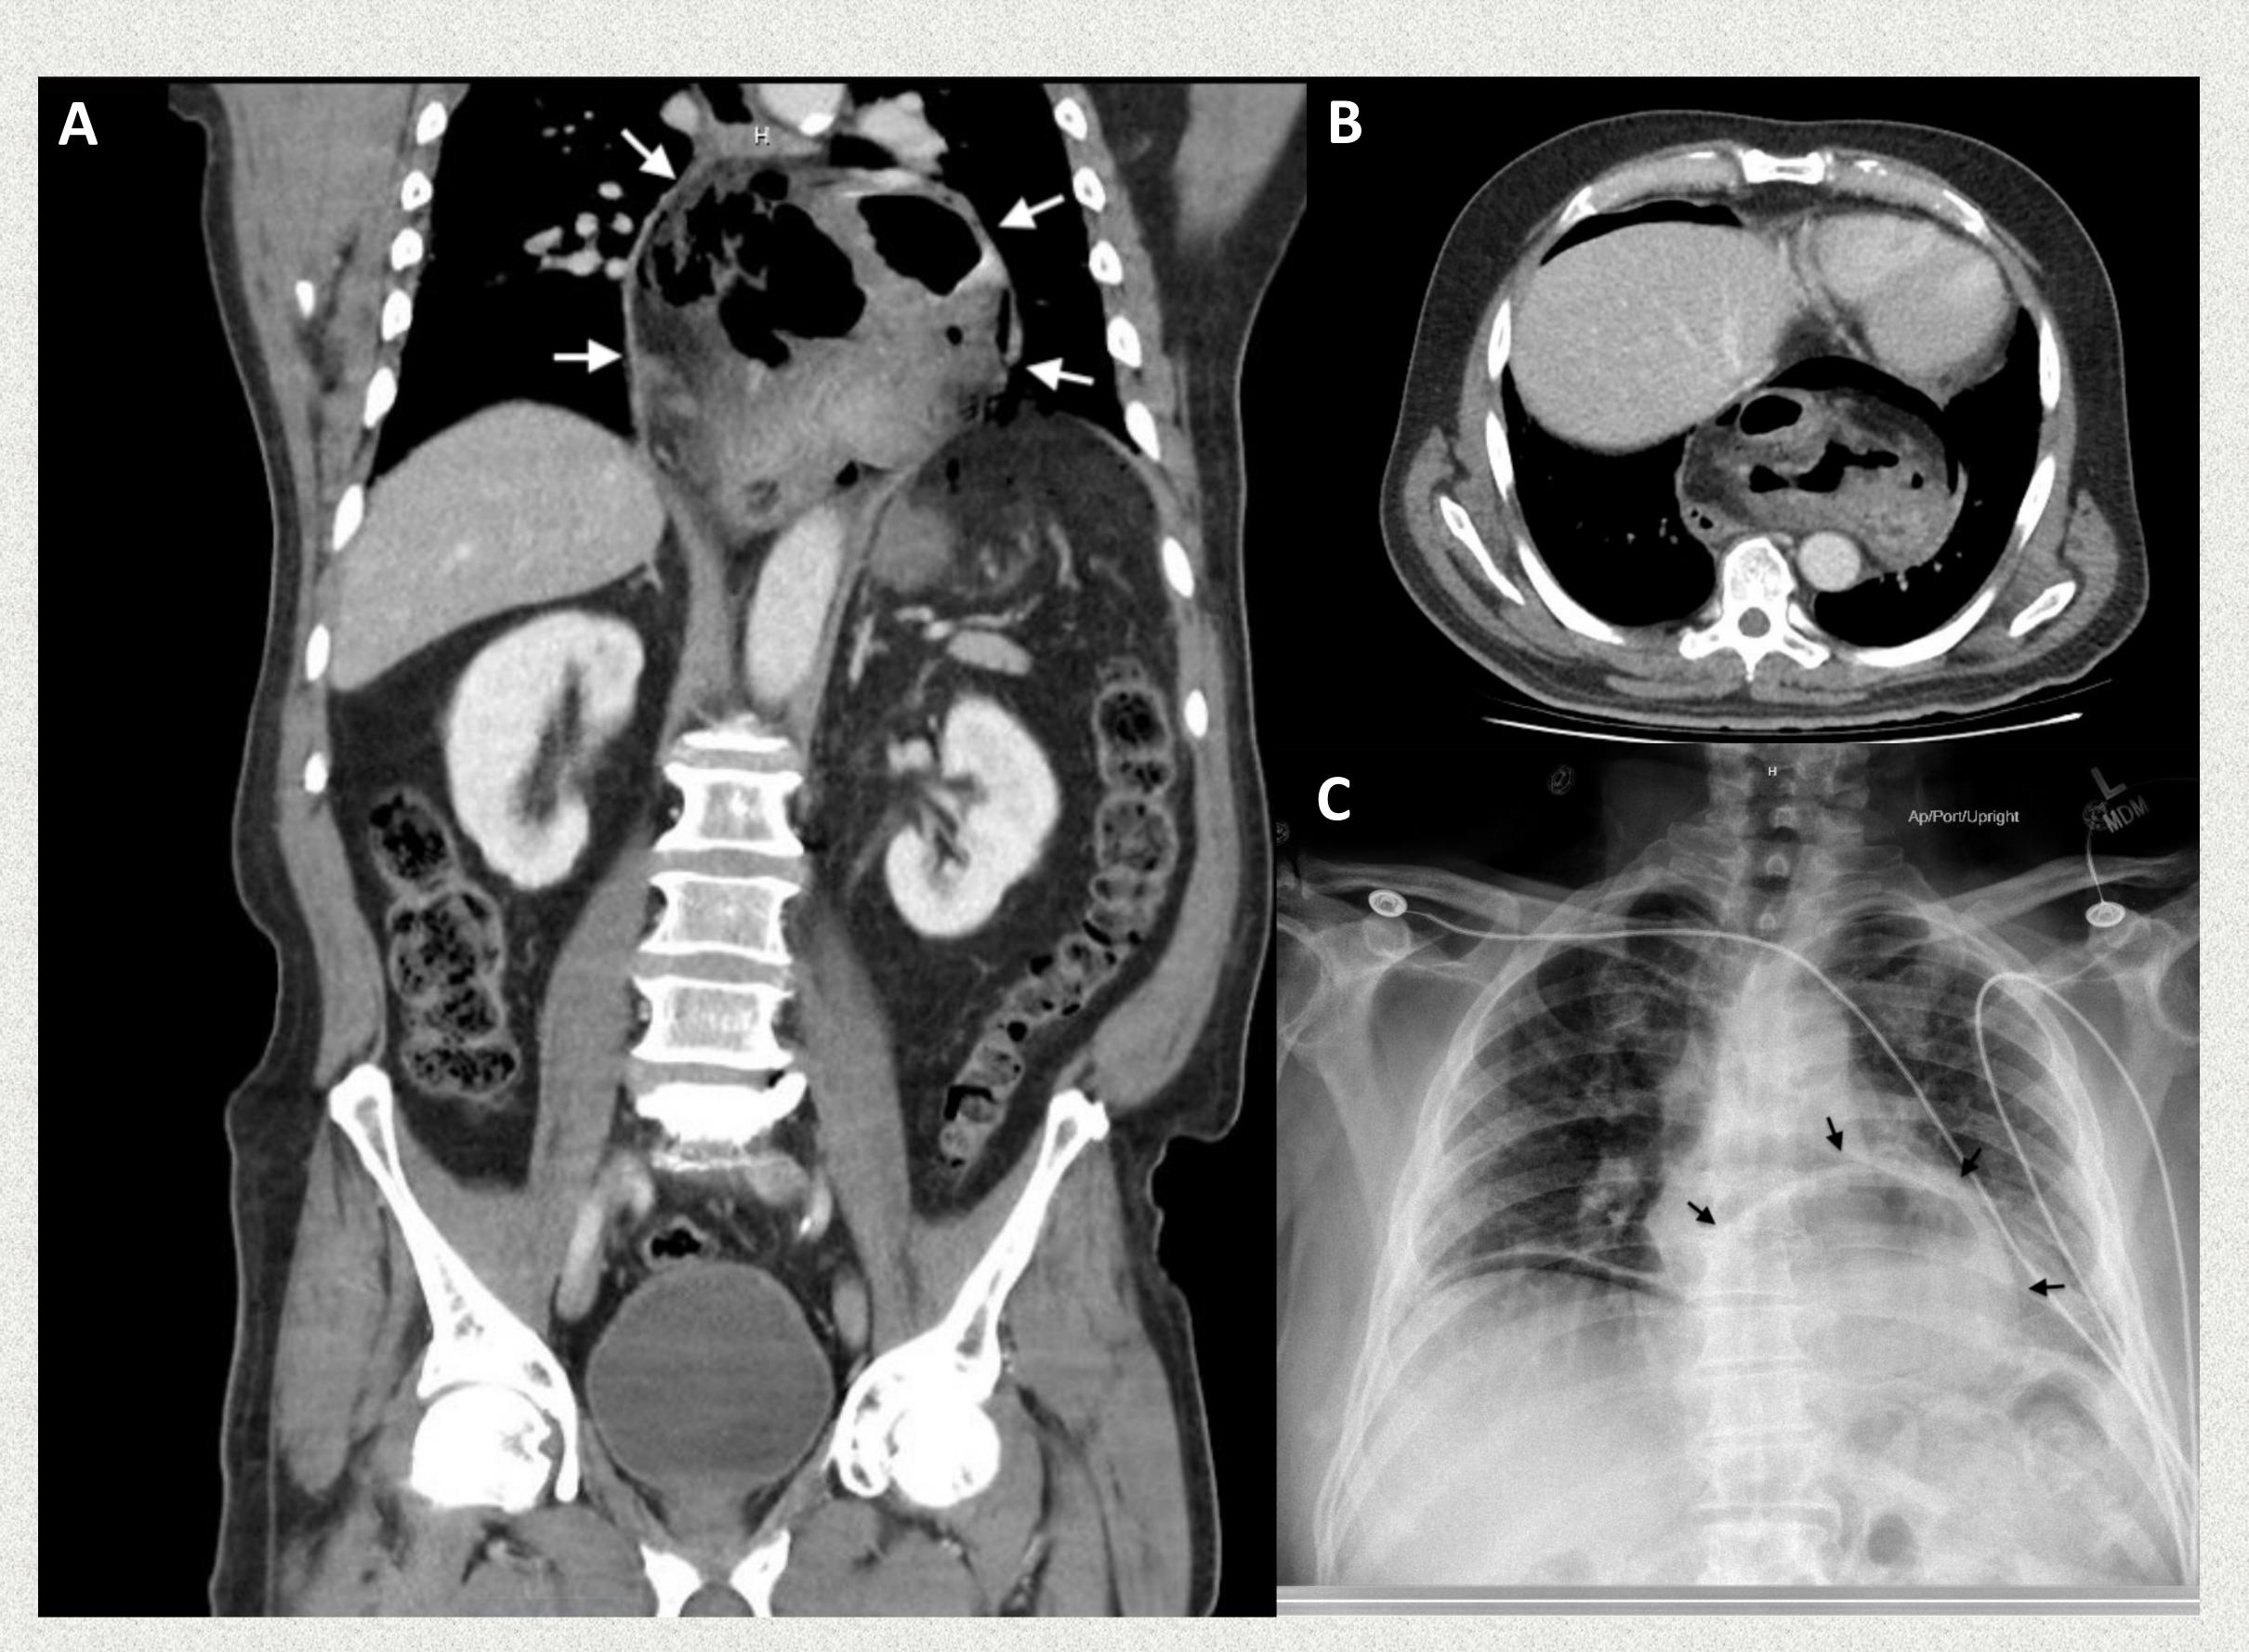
Figure A and B. CT scan of the abdomen and pelvis (coronal and axial view) showing markedly distended stomach in the thoracic cavity.
